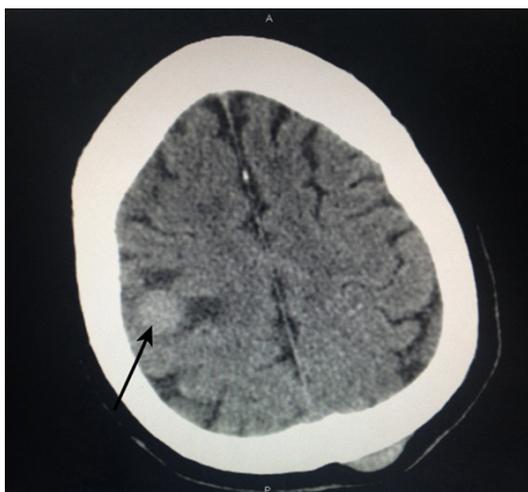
Cranial CT showing the occupying lesion of the right pars frontalis under the cranial plate (arrow) together with a soft tissue mass of the left pars parietalis under the scalp. This further indicates tumor metastasis of the fusocellular sarcoma originating from the dura mater spinalis.
